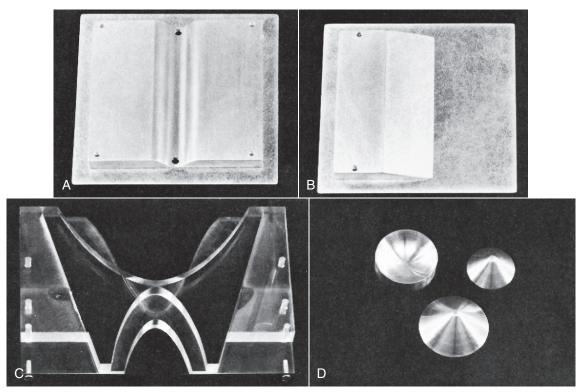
Compensating filters. A, Trough filter. B, Wedge filter. C, "Bow-tie" filter for use in computed tomography. D, Conic filters for use in digital fluoroscopy.
